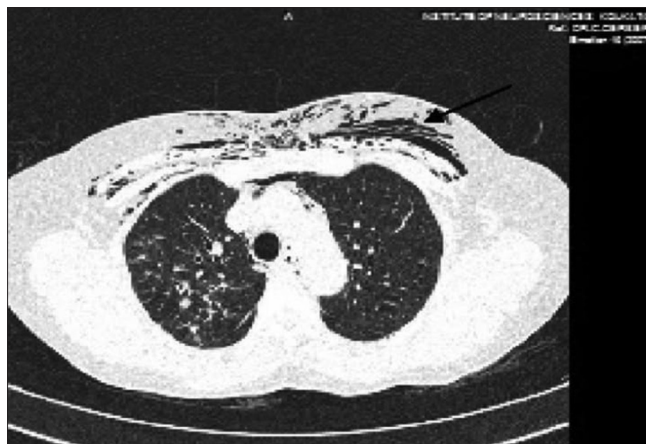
CT Thorax showing subcutaneous emphysema
